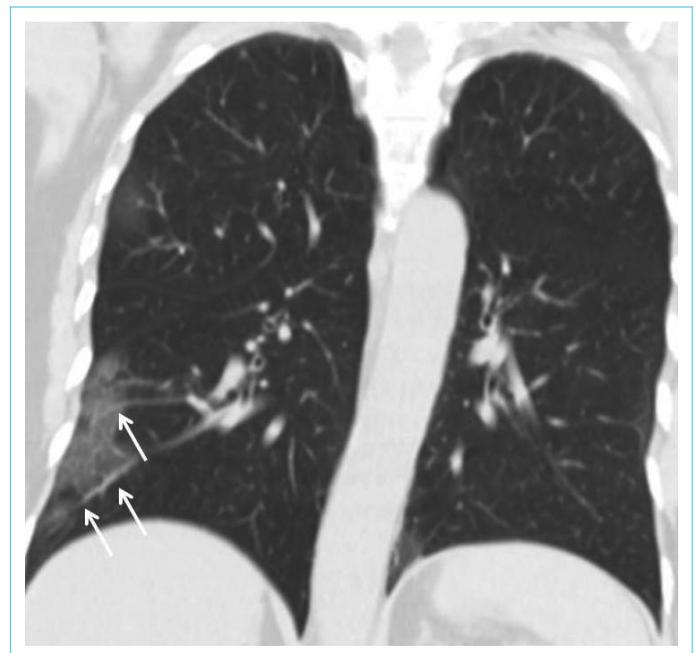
58-year-old woman with a positive RT-PCR. Coronal reformatted unenhanced thorax CT image demonstrates peripheral ground-glass opacities and vascular dilatation (arrows) in the right lung
